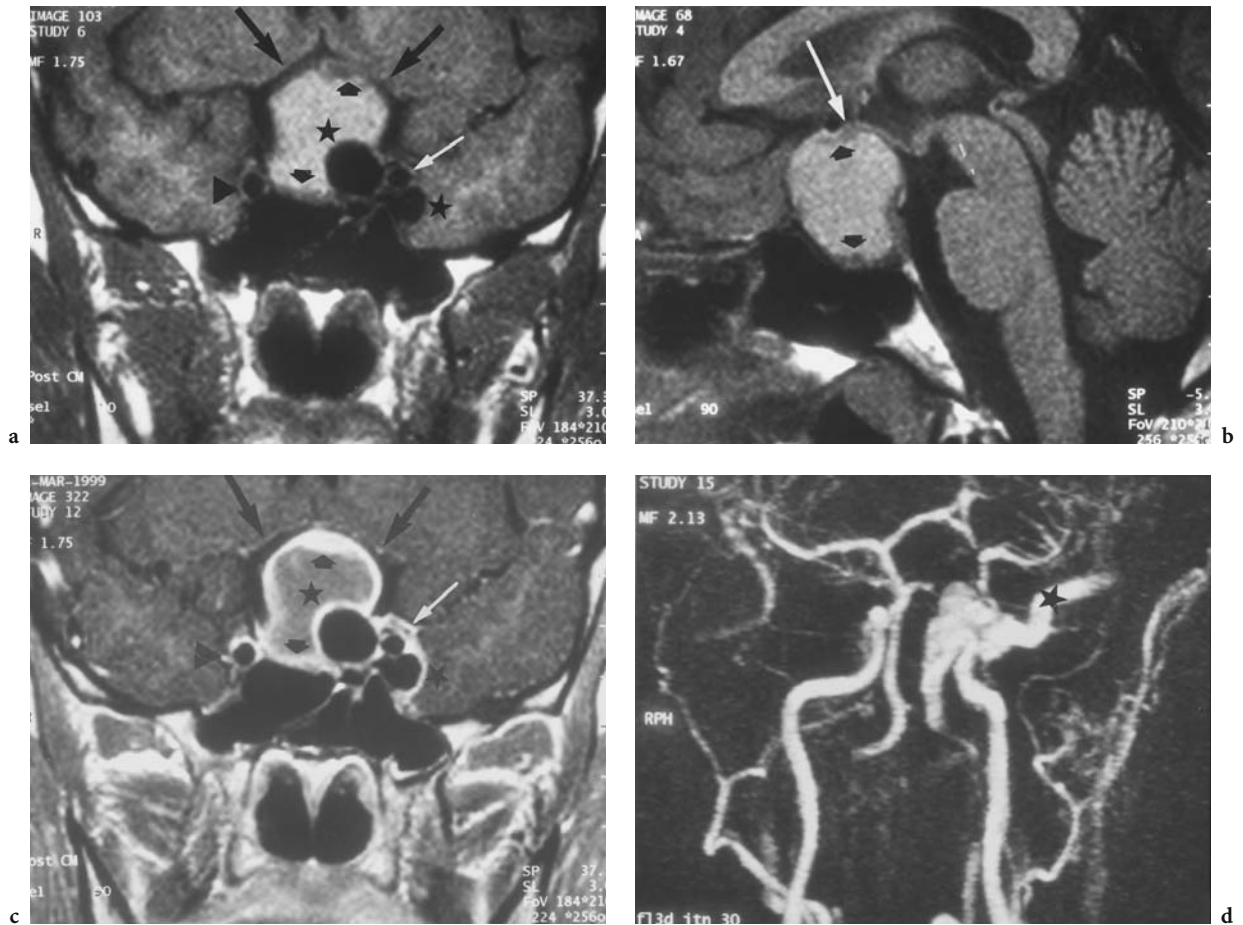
A 25-year-old woman after sellar surgery (external) by transsphenoidal approach for pituitary adenoma 6 months previously. The patient developed proptosis and chemosis of the left eye with pulsatile bruit postoperatively, but ignored the presence of symptoms. Diagnosis: iatrogenic high-flow CCF of the left ICA after transsphenoidal biopsy for intra- and suprasellar pituitary adenoma. MRI: a Coronal T1-weighted native view demonstrating substantial suprasellar extension of the pituitary adenoma with compression and apicalization of both A1 segments (arrows). Note the spherical signal void (stars) medial and lateral of the cavernous segment of the left ICA (white arrow, right ICA: triangle) as well as the small, isointense pituitary gland remnant at the sellar floor and at the upper border of the tumor (short arrows). b Midsagittal T1-weighted native view demonstrating a (neuro-ophthalmologically silent) compression of the chiasm (white arrow) (short arrows: remnants of normal pituitary gland). c Coronal, T1-weighted, contrast-enhanced view (corresponding to a), demonstrating the cystic nature of the tumor and signal enhancement of the pituitary gland remnants. d Coronal contrast-enhanced MR-angiography (3D-TOF) with demonstration of carotid leakage into the ipsilateral cavernous sinus and filling of the superior ophthalmic vein (star). DSA: e AP view of an early phase of left ICA, showing only slight distal filling, but immediate opacification of the cavernous sinus and basal plexus (arrowhead), compare with a, c, d. f Corresponding lateral view with slight opacification of the superior ophthalmic vein (star) and basal plexus (arrowhead), but intense contrast of the cavernous sinus. g Oblique view of the right ICA with contralateral carotid compression, demonstrating the intact Willis' circle and collateral circulation of the left hemisphere, as well retrograde filling of the cavernous sinus fistula. Note the extension of the elevated anterior cerebral arteries (caused by the pituitary mass). h Lateral view of the left vertebral artery with confirmation of the blood supply to the left hemisphere by Pcom. i AP view of the left ICA after balloon occlusion of the fistula, demonstrating antegrade flow in the left ICA. Continued elevation of the A1 segment due to the presence of the tumor (compare with a, c, d). k Corresponding lateral view. A slight contrast loss in the carotid siphon is due to overprojection of the inflated balloon
